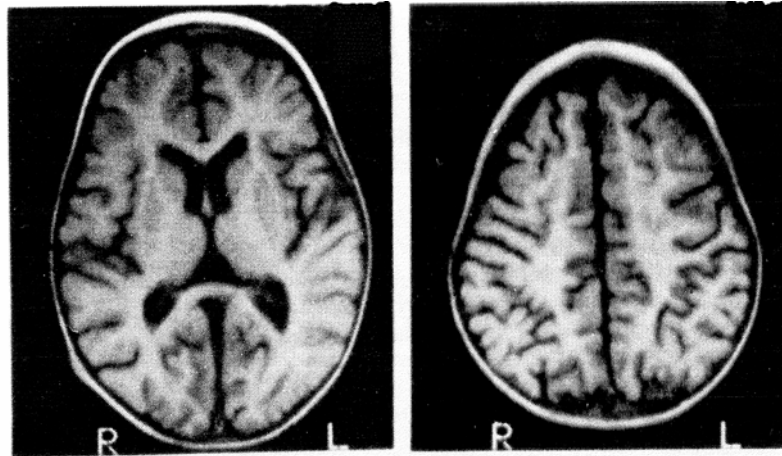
MRI scan in kwashiorkor
